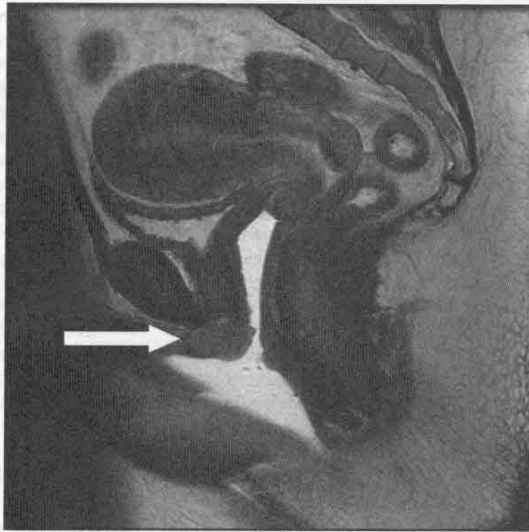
T2-weighted MRI image showing the distal periurethral mass thought to be an infected Skene's gland.
